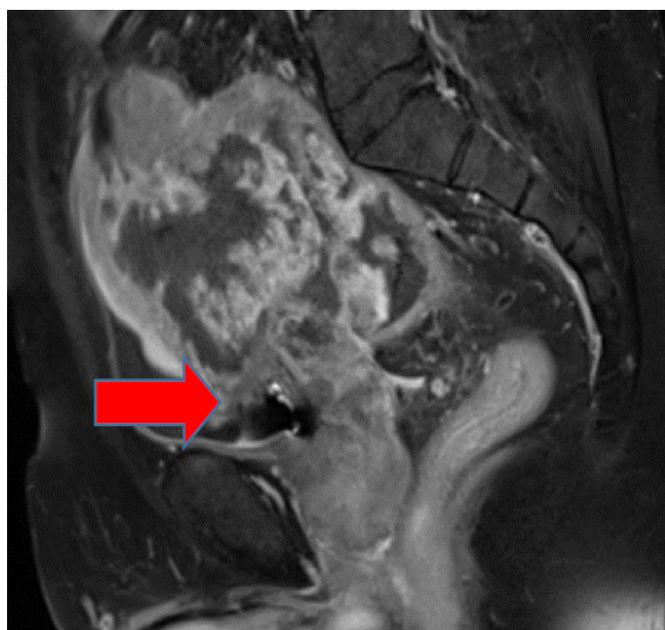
T1 TSE pelvic MRI (arrow pointing towards the tumor, invading the urinary bladder and prostate) – sagittal view
